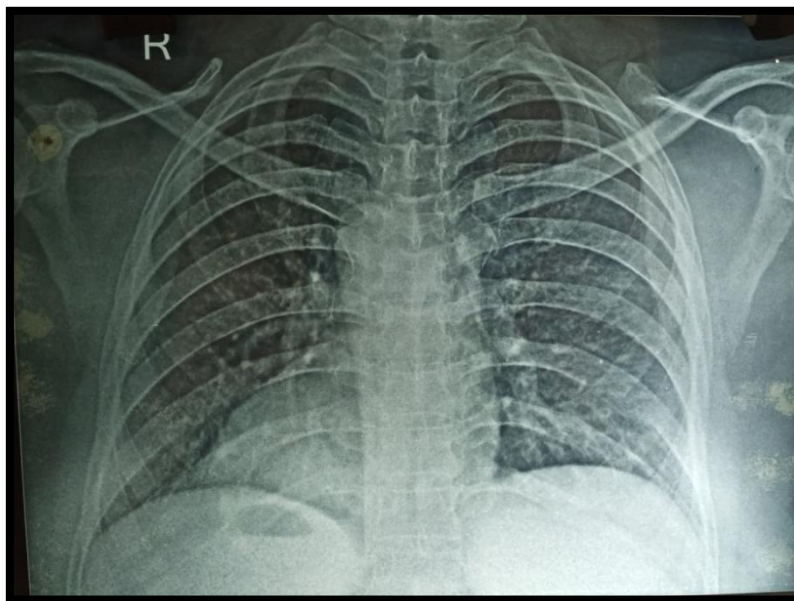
Chest X-Ray PA view showing dextrocardia
